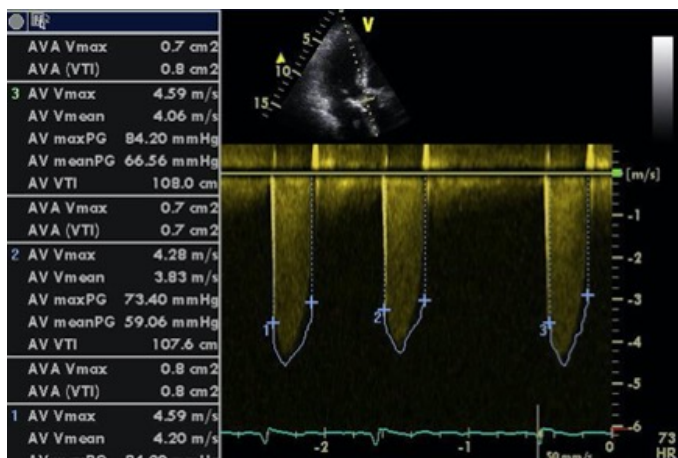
Transesophageal Echocardiography During Presenting Hospitalization: Transesophageal echocardiography reveals A) abnormal cusp motion, marked leaflet thickening, and B) severe stenosis of the bioprosthetic aortic valve.
